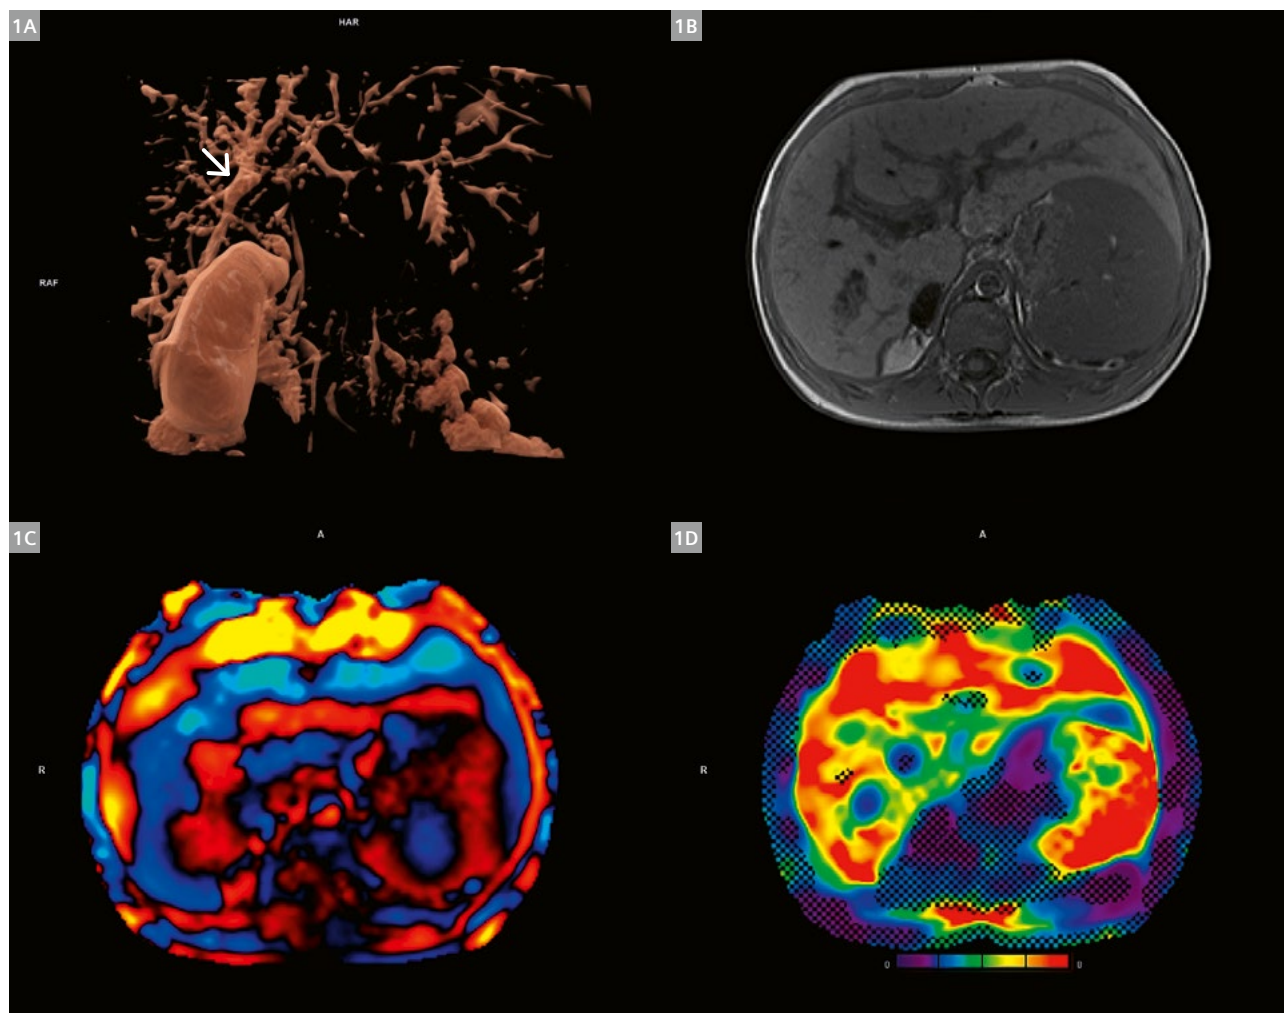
shows a volume-rendered reconstruction of the biliary ducts. Peripheral biliary ducts were significantly dilated, with a diameter of up to 6 mm, and had irregular contours. MRE revealed significantly increased liver stiffness, with a mean value of 5.5 kPa. The spleen was significantly enlarged at 27 cm and had stiffness of 7.0 kPa. Figures 1B, 1C, and 1D show magnitude, wave, and color elastogram with 95% confidence masks. Biopsy performed the day after MRI confirmed significant liver
